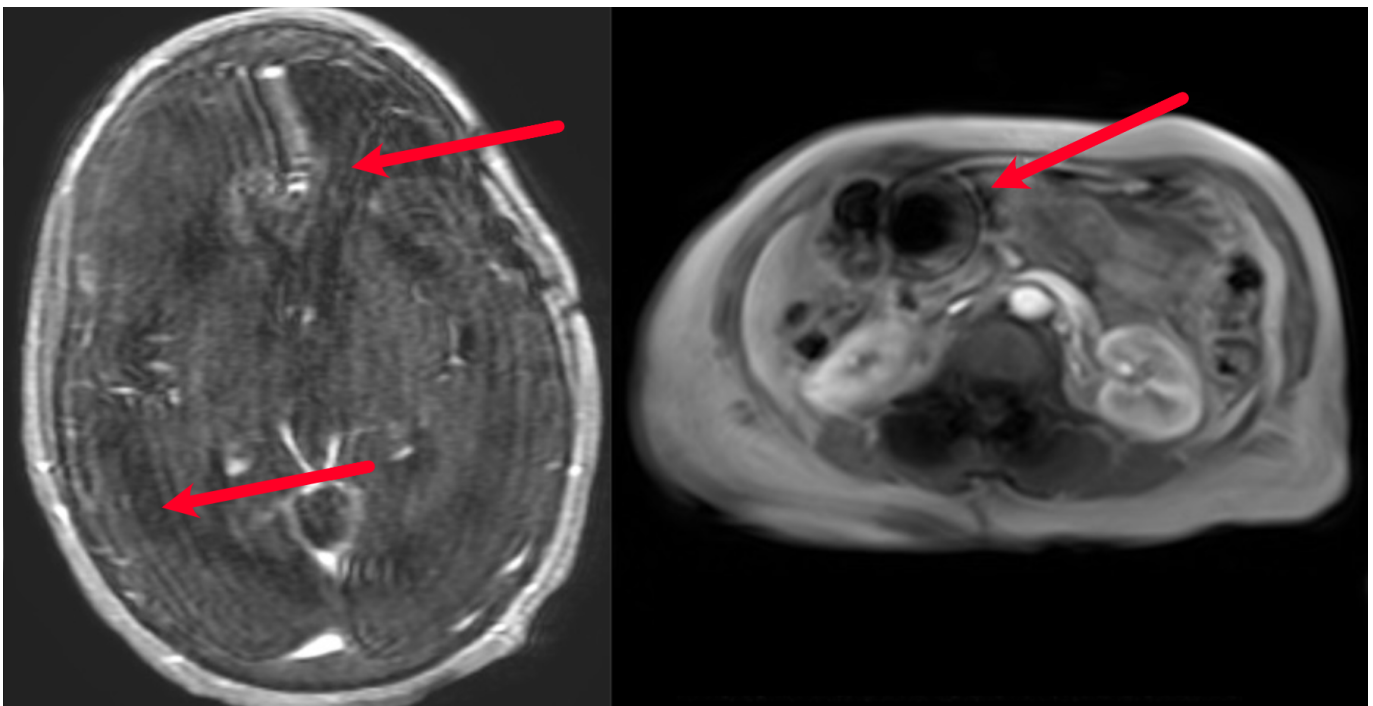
Example images for in-volume motion and susceptibility artifacts in MRI images. Left: a movement during a T_1 weighted brain scan. Right: signal destruction due to metallic stenting in the pancreas (Siemens fast spoiled gradient echo, FSPGR). Images courtesy Mark Shiroishi, USC, Los Angeles, CA, USA and Harrison Kim, UAB, Birmingham, AL, USA.
